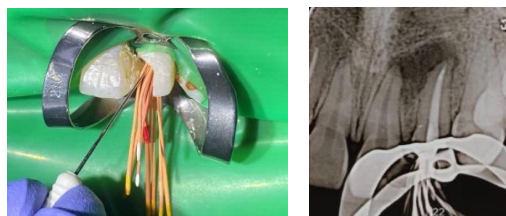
Obturation and Post-Obturation Radiography Tooth 22
